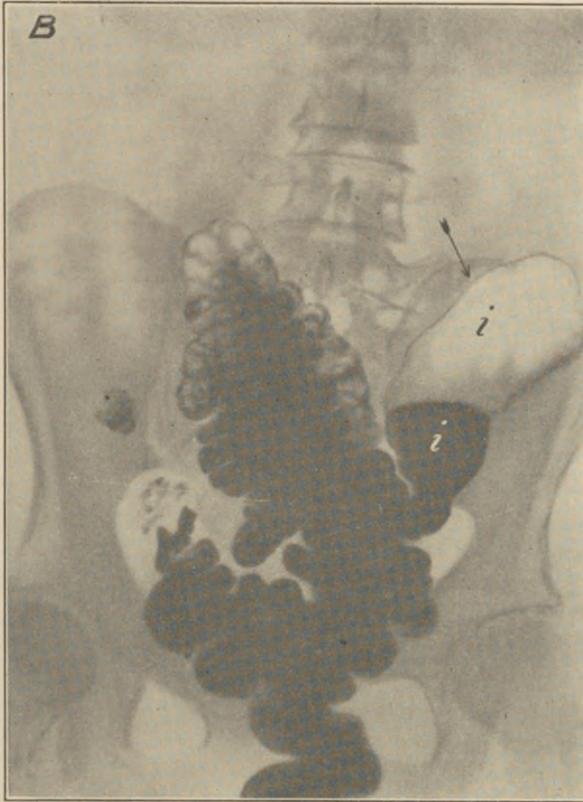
ROENTGENOGRAM SHOWING DISTENDED ILEUM.
